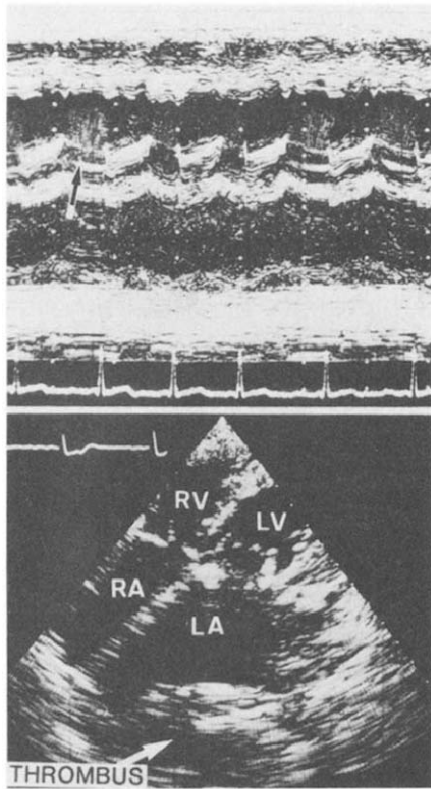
A patient with a smoke-like echo after surgery. Top, The echo was ejected from the prosthetic mitral valve into the left ventricular cavity as indicated by an arrow. The smoke-like echo in the left atrial cavity was not obvious in this image. Bottom, Apical four chamber view demonstrated a large thrombus (arrow) in the left atrium (LA) on the 23rd postoperative day. LV = left ventricle; RA = right atrium; RV = right ventricle.
